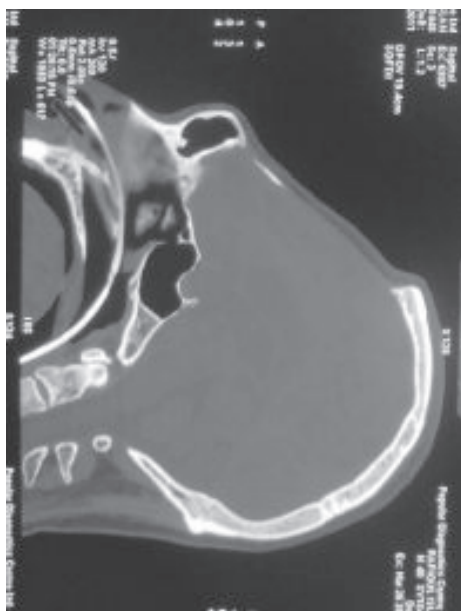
Frontal craniectomy in sagittal Section of CT brain
